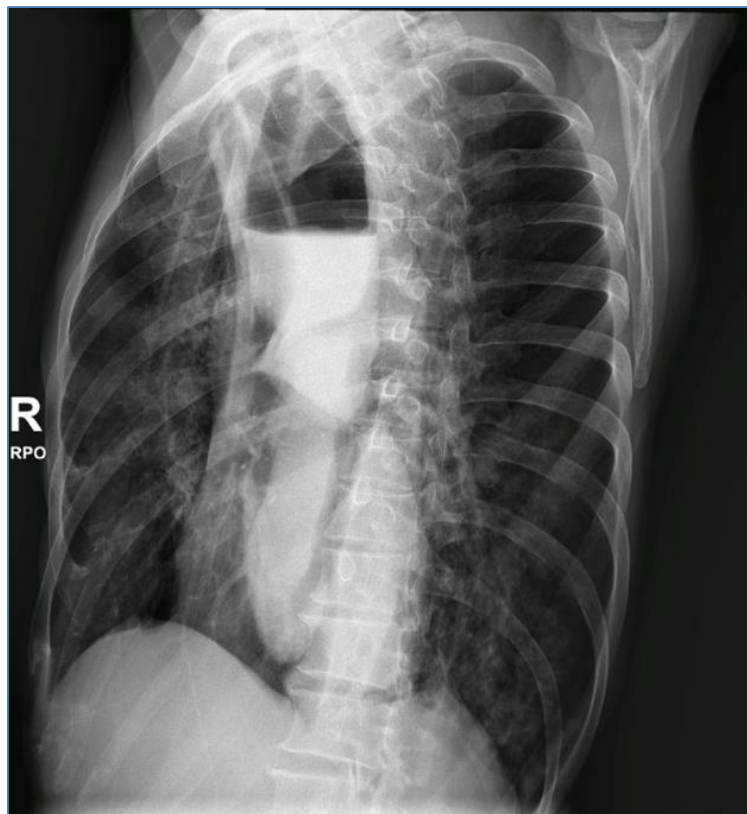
Chest X-ray with contrast, Right Posterior Oblique (RPO) Position
